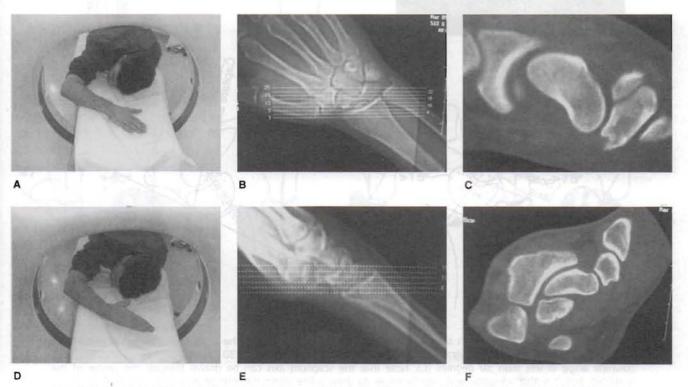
CT of the scaphoid is easier to interpret if the images are obtained in planes defined by the long axis of the scaphoid. To achieve this, the patient lies prone on the table with the arm overhead. *A*, For sagittal plane images, the forearm is held pronated (palm down) and the hand lies flat on the table. The forearm crosses the gantry at an angle of approximately 45 degrees (roughly in line with the abducted thumb metacarpal). *B*, Scout images are obtained to confirm the appropriate orientation and ensure that the entire scaphoid is imaged. Sections are obtained at 1-mm intervals. *C*, Images obtained in the sagittal plane are best for measuring the intrascaphoid angle. *D*, For coronal plane images, the forearm is in neutral position. *E*, Scout images demonstrate alignment of the wrist through the gantry of the scanner. F, Interpretation of the images obtained in the coronal plane is straightforward. (From Ring D, Jupiter JB, Herndon JH: Acute fractures of the scaphoid. J Am Acad Orthop Surg 8[4]:225–231, 2000.)
